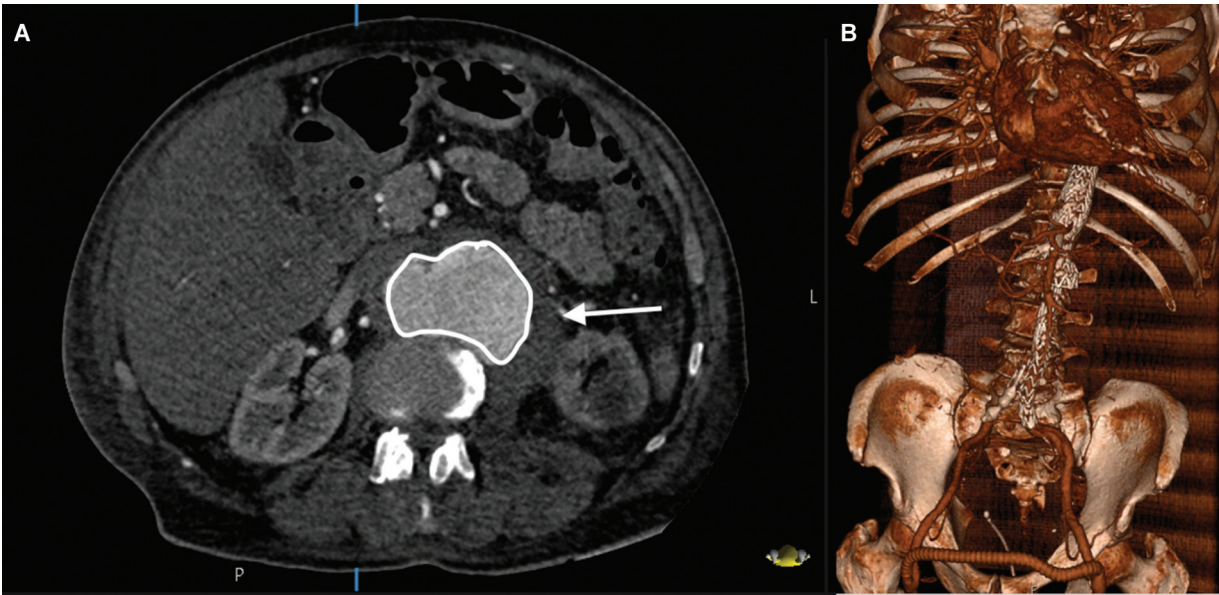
Juxtarenal mycotic aortic and iliac aneurysm (MAA) on computed tomography (CT) angiographic imaging with (A) peri-aneurysmal collection/stranding (arrow) with (B) postendovascular management in three-dimensional reconstruction.
